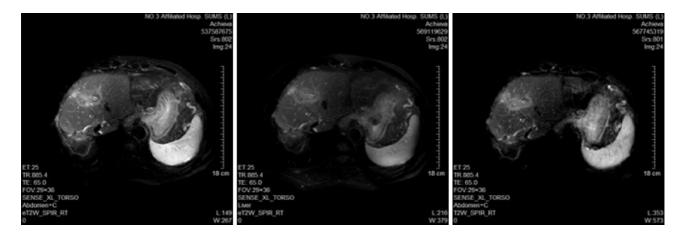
Patient information. A: Changes in alpha fetoprotein during treatment. B: Mutation map of adenomatous polyposis coli domains; C: Changes in tumor masses by magnetic resonance imaging before and after aspirin treatment. APC: Adenomatous polyposis coli; TACE: Transcatheter arterial chemoembolization.
